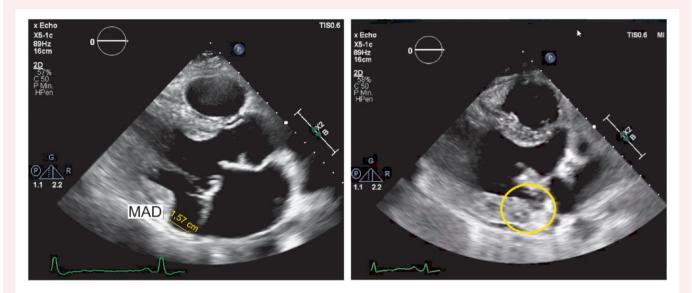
Transthoracic echocardiography image of mitral annular disjunction measuring 1.57 cm 7 months after cardiac arrest (left image) vs. transthoracic echocardiography image after surgery (right image). During surgery, the ventricular myocardium was lifted; mitral annular disjunction (supposedly within the circle) is not present anymore. MAD, mitral annular disjunction.
